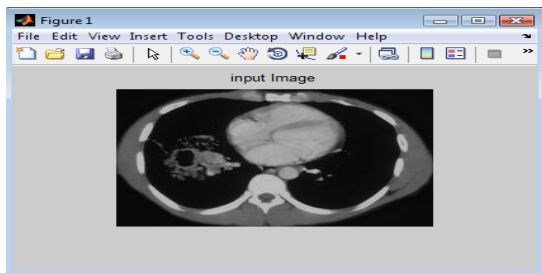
Input Image-Thoracic CT.
